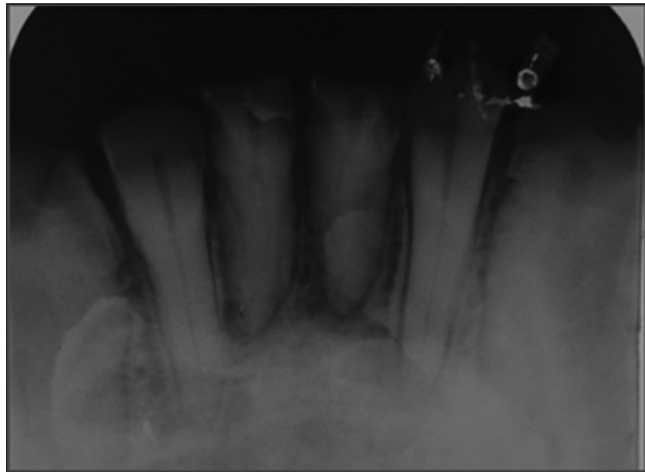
Intraoral periapical showing periapical rarefaction with all the mandibular incisors.
